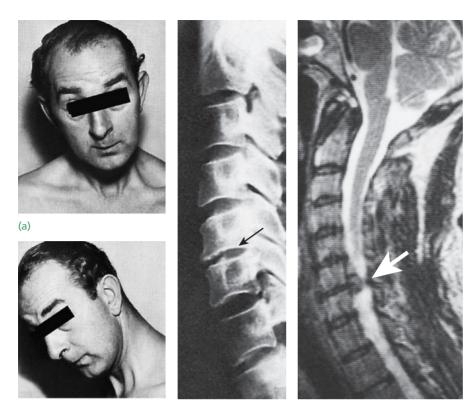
Acute disc prolapse (a,b) Acute wry neck due to a prolapsed disc. (c) The intervertebral disc space at C5–C6 is reduced. (d) MRI in another case showing a large disc prolapse at C6–C7.
